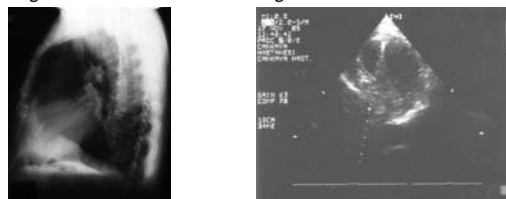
lateral chest x-ray reveal a needle near the heart in the chest cage
